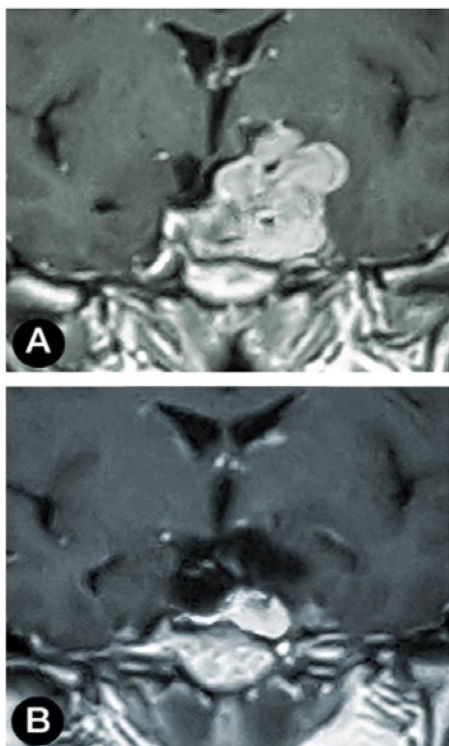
(A) MRI coronal view before treatment showing macroprolactinoma compressing the left temporal lobe and invading the left cavernous sinus. (B) Significant tumor shrinkage after 6 months of treatment with CAB (up to 1mg twice/week).
